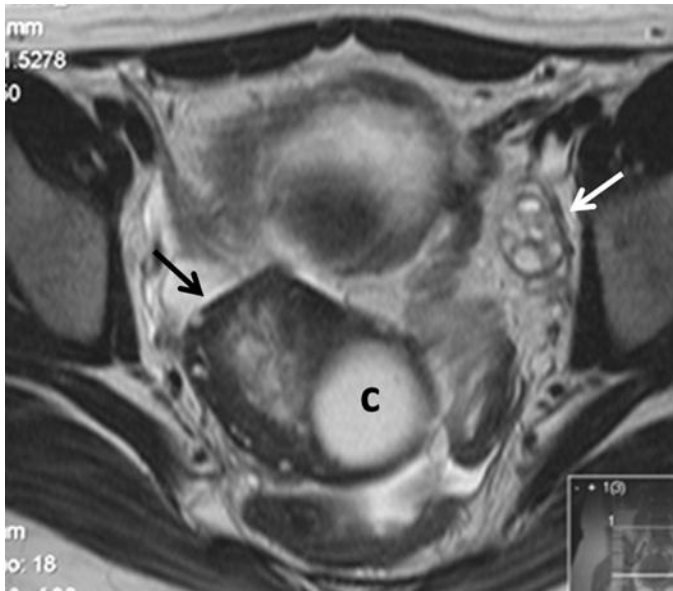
Magnetic resonance imaging findings in ovarian torsion with associated serous cystadenoma. Axial T2-weighted image shows enlarged right ovary (*black arrow*), located in the cul-de-sac at the posterior midline, with T2-weighted hyperintense cyst (*c*). The ovarian stroma demonstrates heterogeneous signal intensity due to hemorrhage and edema, and there are multiple small peripheral follicles. The left ovary (*white arrow*) is normal in size and appearance.
